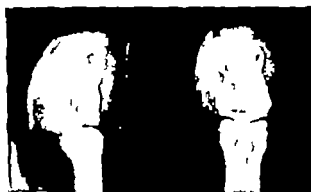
Roentgenogram of a giant-cell tumor in the terminal phalanx of a thumb a rare location for it. This tumor recurred within a year after curettement. The surgeon elected to do a second curettement because he was loath to sacrifice the thumb, but is aware of the necessity for ablation in the event that the tumor recurs again.
